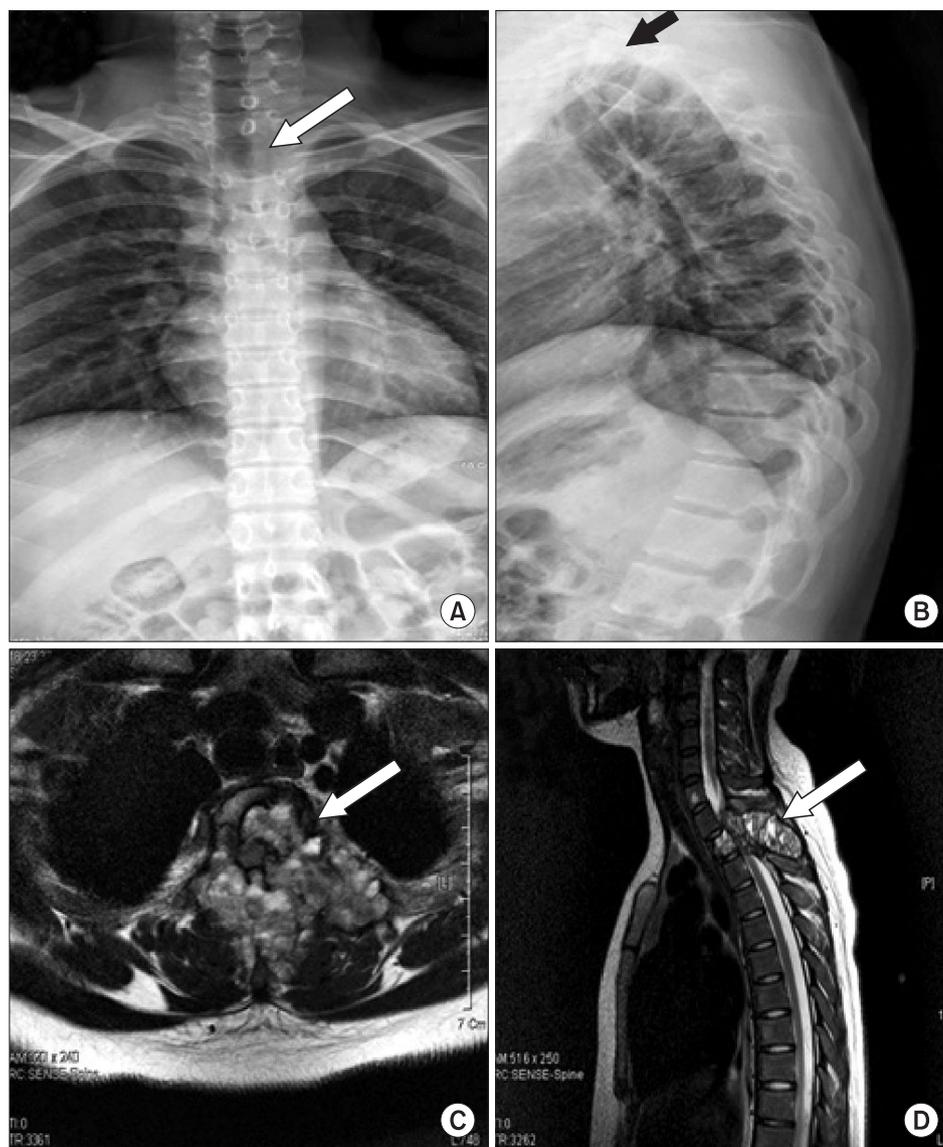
(A) Plain radiographs showed an osteolytic bony lesion at T2 vertebra (arrow), onset time of weakness, anterior-posterior view. (B) Lateral view. (C) Magnetic resonance imaging suggestive of giant cell tumor (arrow). There is signal change in the spinal cord at the T2 vertebra level suggesting a cord compression, T2 axial view. (D) T2 sagittal view.
